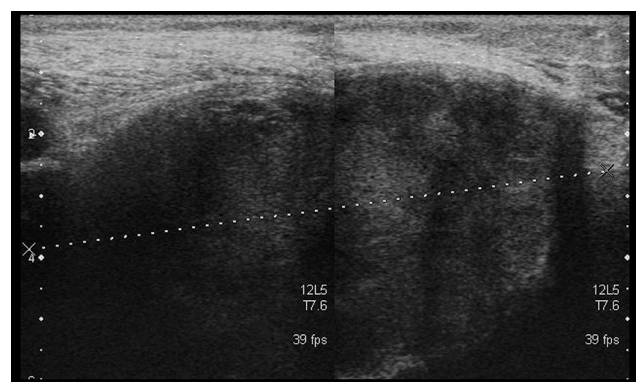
Ultrasound. Transversal view. Heterogeneous popliteal cyst. Appearance corresponding to fibrinous blood clot.
